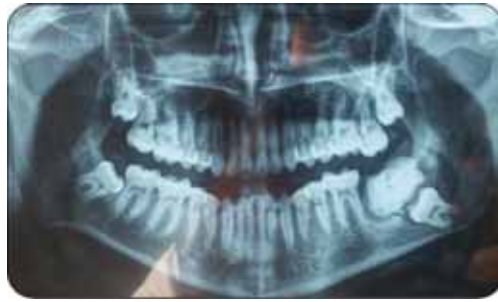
Orthopantomograph showing Opaque Lesion with Impacted 38.
